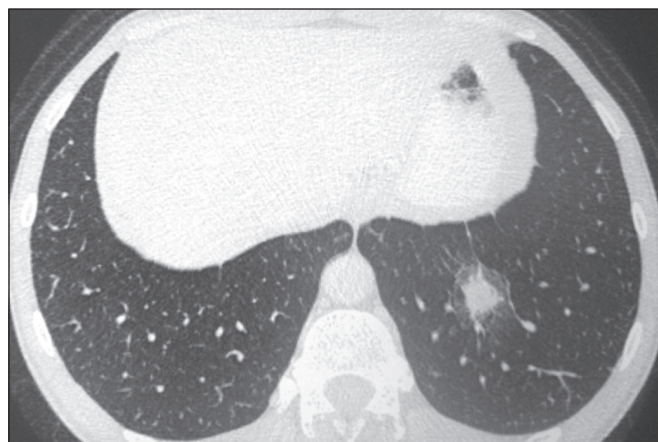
CT of a 47-year-old man with positive serology, showing a nodule surrounded by ground-glass attenuation (the halo sign) in the left lower lobe.
